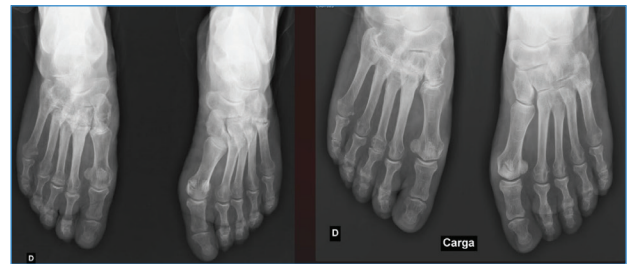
Non-weightbearing (Figure 1A) and weightbearing (Figure 1B) anteroposterior radiographs demonstrated a Freiberg Disease
